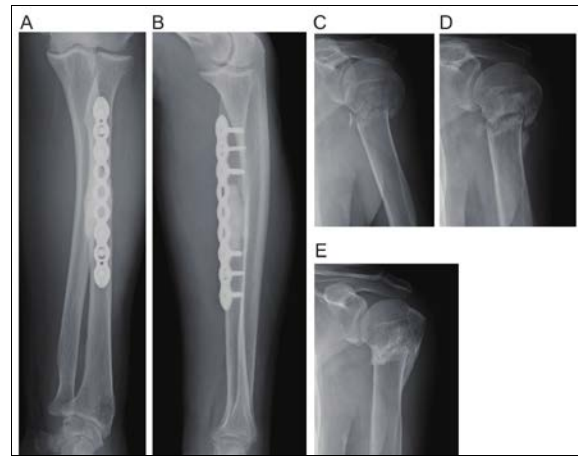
Postoperative images of the left radial fracture and bone healing of the left proximal humeral fracture Plain X-ray AP view (A) and lateral view (B) one year after open reduction and internal plate fixation and open biopsy of the left radial fracture. Radiographic images of the left proximal humeral fracture 1 month before (C), 3 months (D) and 11 months after (E) parathyroidectomy are shown.
